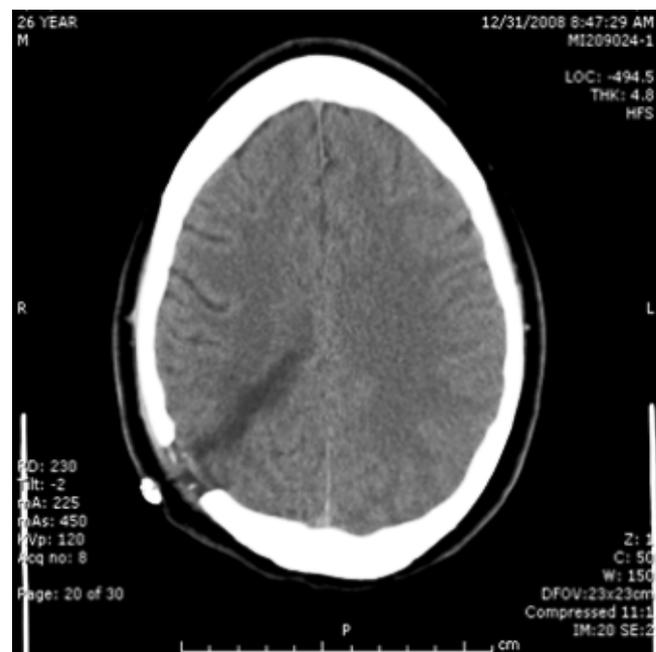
Head computed tomography scan without contrast showing an extended band-shaped hypodensity in the right postero-parietal region representing the bullet trajectory.
